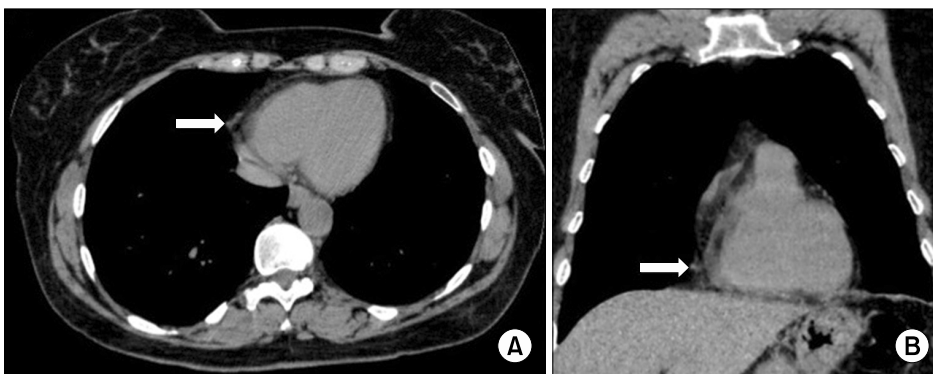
Three years after the initial diagnosis, (A) axial and (B) coronal thoracic computed tomography scans revealed complete resolution of the pericardial cyst. An area of slight pericardial thickening can be observed on the right side of the heart (arrows).
